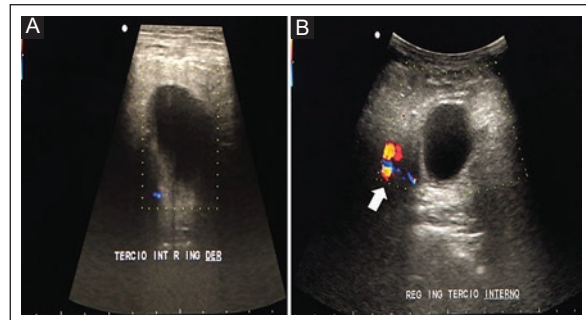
Color Doppler US in the groin and right femoral region of a 59-year-old male patient. A: anechoic tubular image was identified with a linear probe, posterior acoustic reinforcement 3 cm in diameter with increased echogenicity of adjacent fatty planes; no vascular alteration or hernial defect was observed. B: a convex probe in the transverse plane demonstrated its medial and anterior location to the right iliac vessels (arrow).
